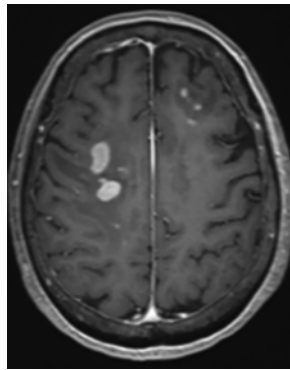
Brain MRI of relapsed primary central nervous system lymphoma. Brain MRI showed multifocal recurrence of lymphoma on post-contrast T1 image after 2 cycles (8 weeks) of Temozolomide (TMZ)+Rituximab (RTX) therapy, at 20 months since diagnosis.
